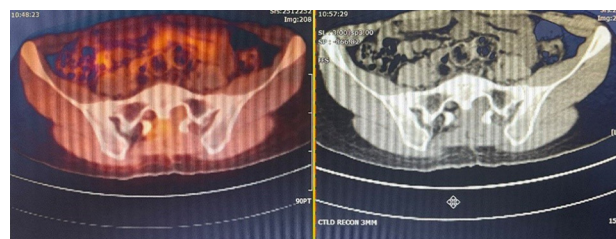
The whole-body fluorodeoxyglucose positron emission tomography (FDG-PET) after the 2nd episode of tumor recurrence exhibited low-grade FDG-avid soft tissue density in the posterior sacral area, as well as a local active lesion in the left lateral process of the S1 vertebra.
